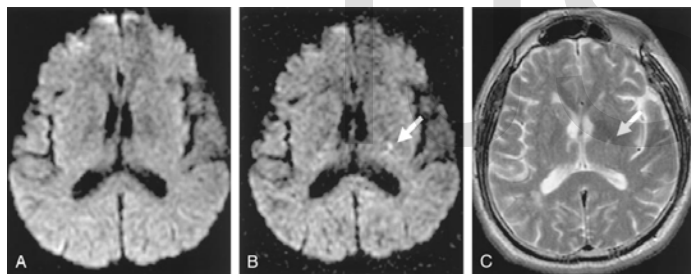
A-C, A 63-year-old man who had right hemiparesis for 6 hours. Abnormal hyperintensity is noted at left posterior limb of internal capsule on b =2000 image (B, white arrow) but it is not definite on b = 1000 image (A). Follow-up T2-weighted image obtained 2 days later shows a small hyper-intense lesion in the same location (C, white arrow). (Image used with permission from cgchoi) [2].
